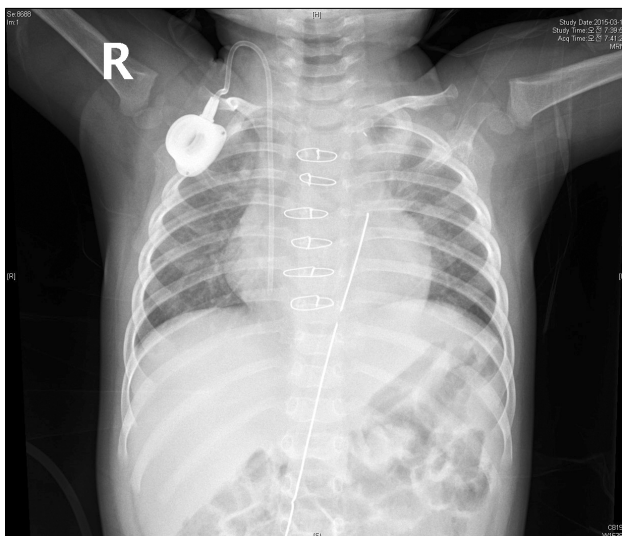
Chest X-ray taken after the anterior mediastinal mass was resected.
